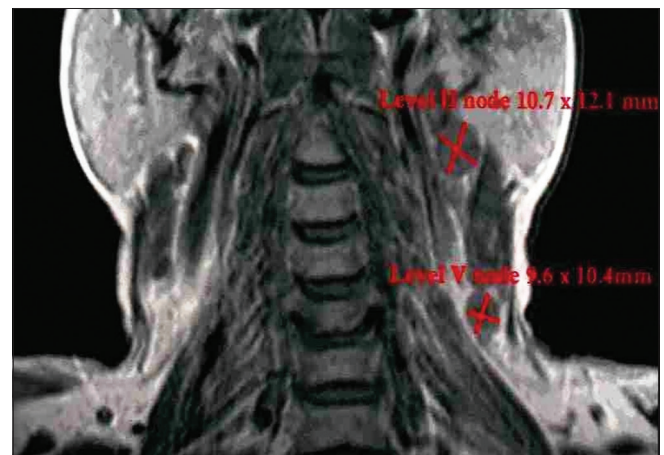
Lymph node size on magnetic resonance imaging image (coronal view)
